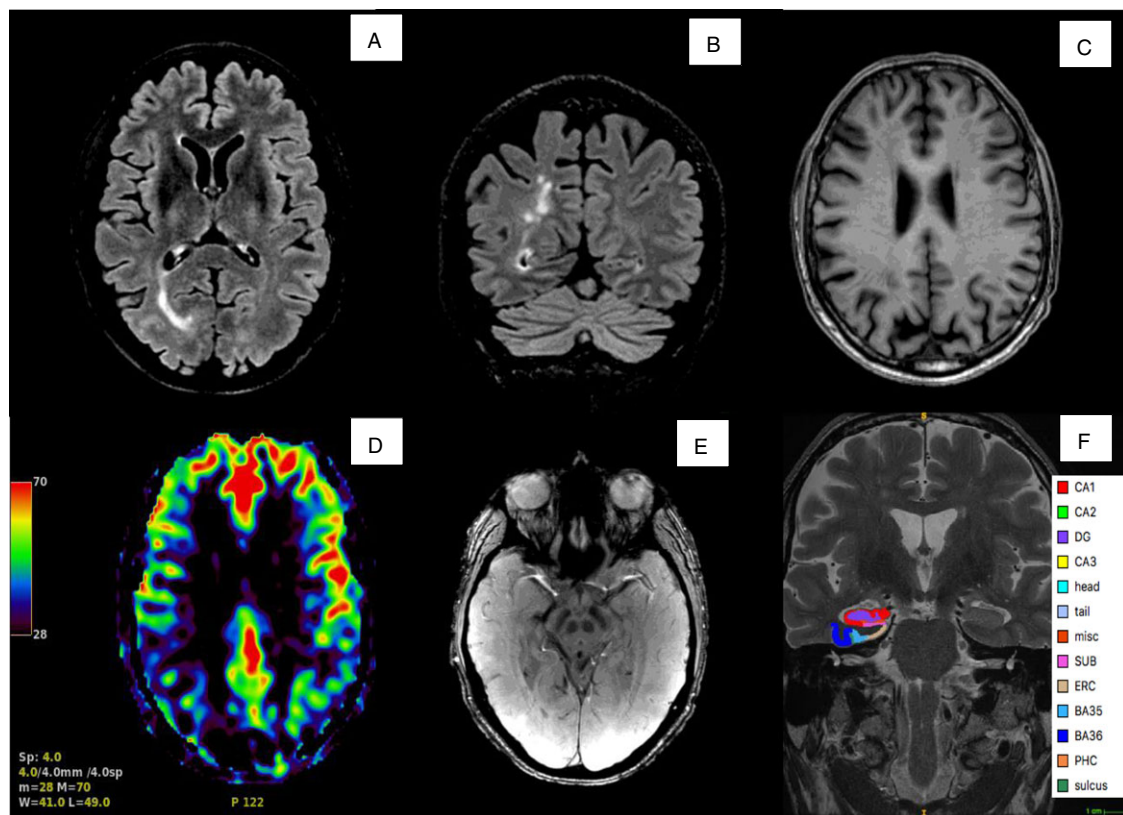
On top, axial (a) and coronal (b) fluid attenuated inversion recovery (FLAIR) showing occipital-parietal white-matter cortico-subcortical suspicious for microgliosis, and axial T1-weighted MRI (c) with correspondent atrophy in the precuneus regions. On bottom, ASL perfusion analysis (d) displaying an hypoperfusion of parietal lobe more prominent in the right hemisphere, susceptibility-weighted angiography (SWAN) sequence (E) with the bilateral lack of the “swallow tail” sign, and coronal high-resolution T2 with hippocampal subfields analysis [F] through ASHS (Automatic segmentation of hippocampal subfields) algorithm). CA = cornu ammonis; DG = dentate gyrus; SUB = subiculum; ERC = entorhinal cortex; BA35/36 = Brodmann area 35/36 (which together form the perirhinal cortex); CS = collateral sulcus.
